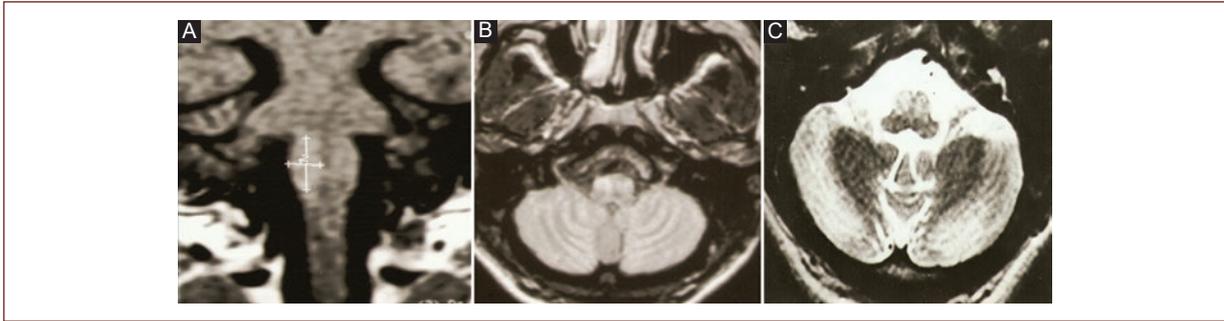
(Patient 2) Magnetic resonance imaging. Coronal T1 A: axial FLAIR B: and axial T2 C: weighted imaging showing olivary hypertrophy degeneration in a patient with progressive ataxia.
